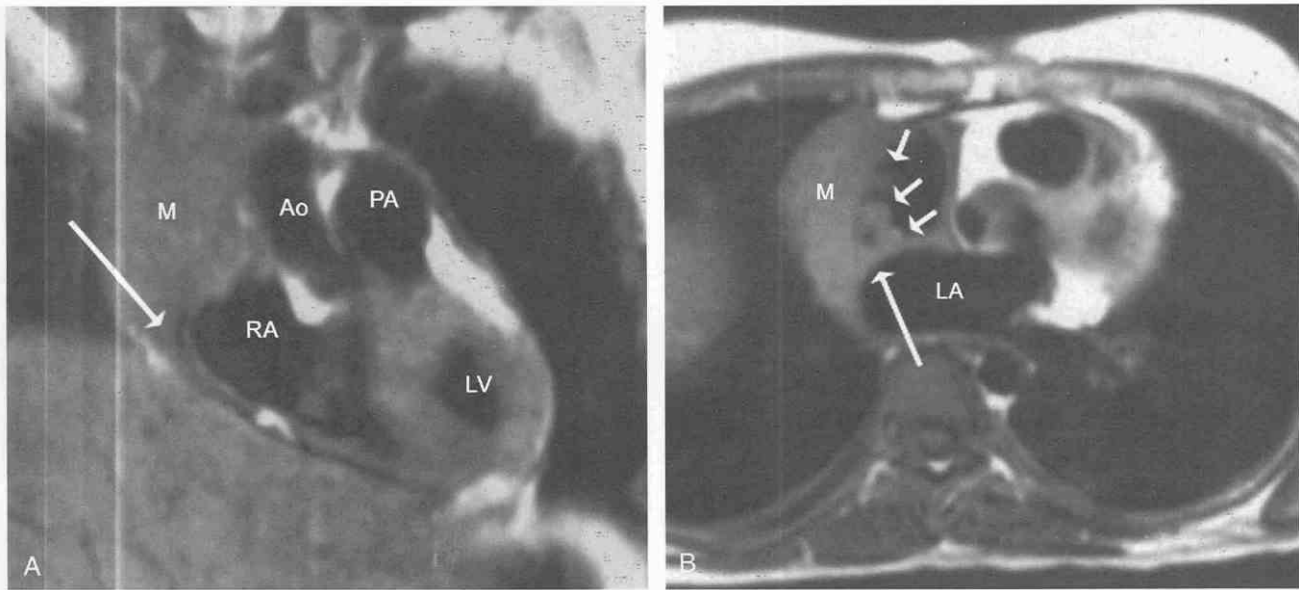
MR image obtained from a 16-year-old child with lymphoma. A, Coronal spin-echo image obtained through the ascending aorta (Ao) and main pulmonary artery (PA). A bulky, homogeneous, intermediate signal intensity mass is seen along the superior right cardiac border that involves the pericardial space (*arrow*) but seems to spare the right atrium. LV, left ventricle; M, mass; RA, right atrium. B, Axial spin-echo acquisition through the superior aspect of the right atrium and aortic valve. The paracardiac and pericardial components of the mass (M) are again seen. In this image, however, there is nodular involvement (*short arrows*) within the right atrium as well as infiltration of the interatrial septum (*long arrow*).
